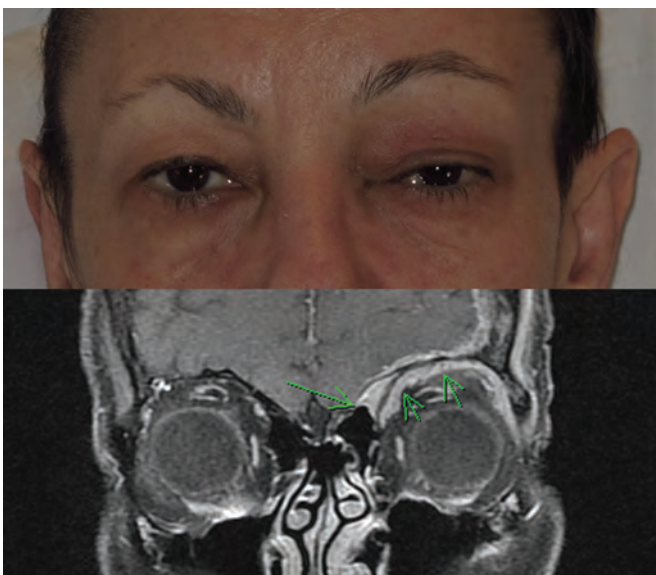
Clinical photograph and T1 contrast enhanced fat saturated magnetic resonance image of the orbits in the coronal plane demonstrating left superior orbital metastasis causing proptosis and diplopia.
